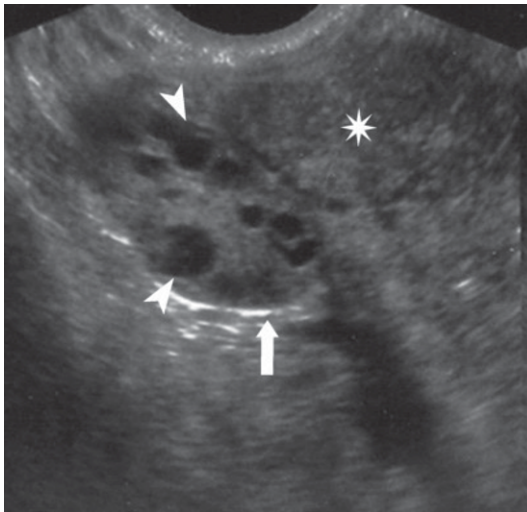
Ultrasonography. Transvaginal approach. Abscessed oophoritis. The right ovary (arrow) appears swollen, heterogeneous with liquefied necrosis (arrowheads). The adjacent uterine tube (asterisk) is distended by corpuscular liquid
